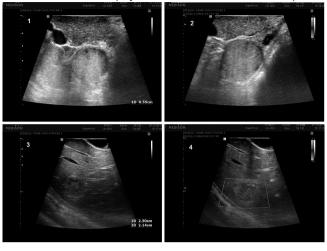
Intraoperative localization of the lesion with the use of ultrasound associated palpation, numbered according to the sequence of images acquired with analysis of the lesion, the vascularization and relation to the pancreatic duct
